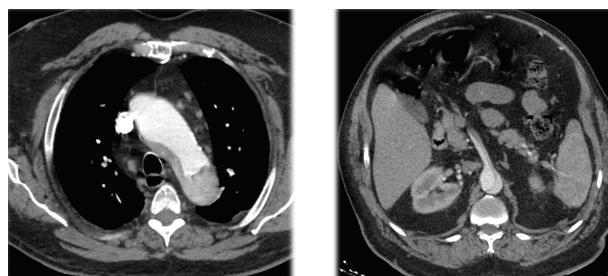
Axial CTA images of the chest and abdomen, with dissection flaps extending into the aortic arch and superior mesenteric artery (SMA) with thrombosis of the false lumen.
